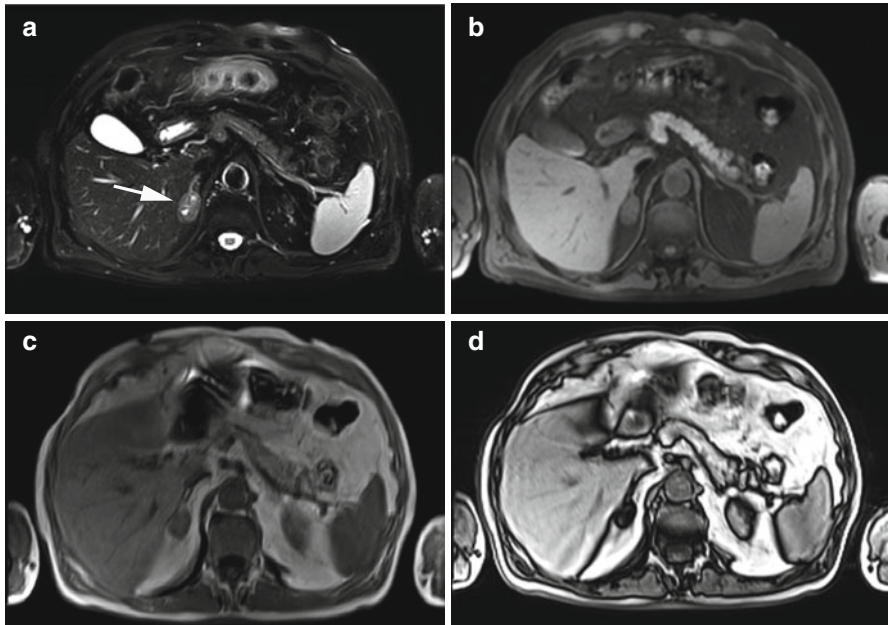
A 65-year-old male subject without symptoms at the time of whole-body screening MRI. (a) Fat-saturated T2w TSE image shows a heterogeneous mass with a liquid center measuring $3.3 \times 2.1 \times 2.5$ cm (arrow). (b) On fat-saturated T1w FLASH image, the mass is isointense to muscle. (c, d) Chemical shift imaging allows characterization of the mass. The characteristic decrease in signal intensity on the out-of-phase image (d) indicates a fatty tumor. The appearance is typical of an adenoma
